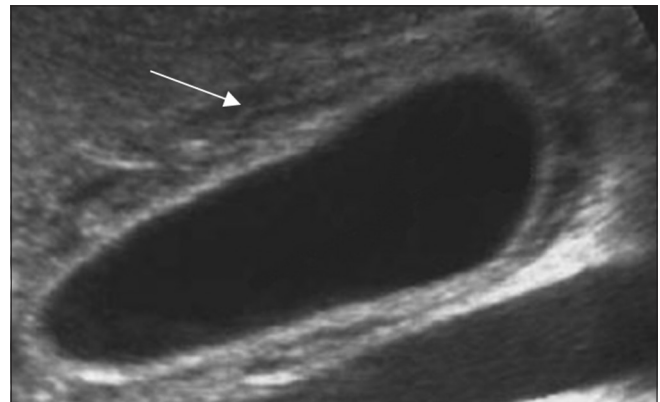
A 22 years male patient with dengue fever, ultrasound shows thickened and edematous gall bladder wall (arrow)
